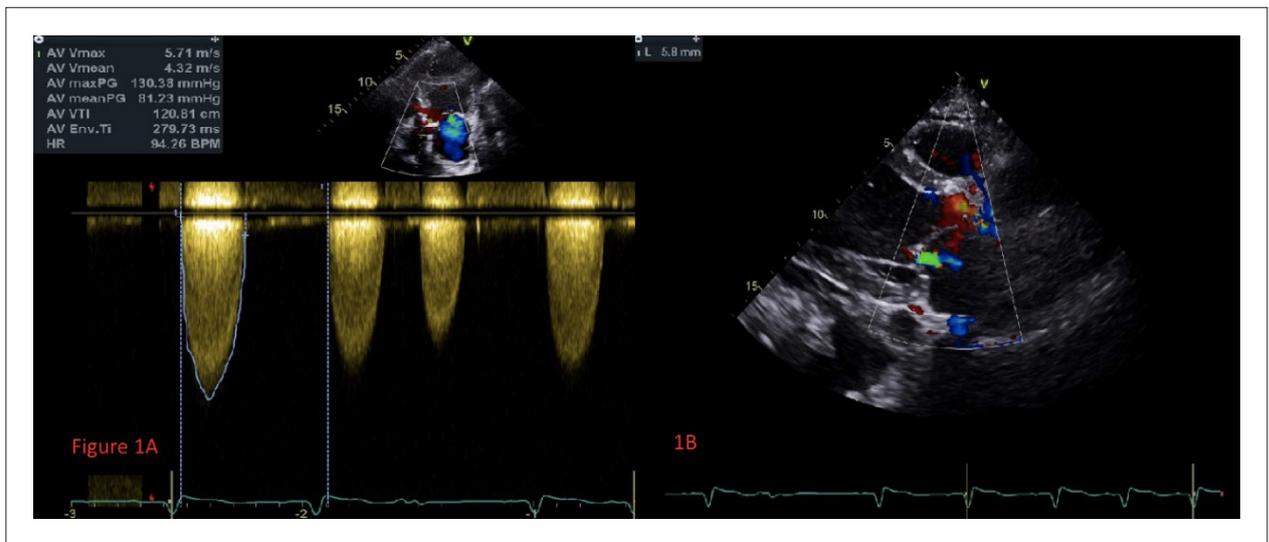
A and B) Preoperative echocardiography indicated that aortic valve velocity and pressure gradient increased, aortic valve lobe calcified, and severe aortic stenosis occurred.
